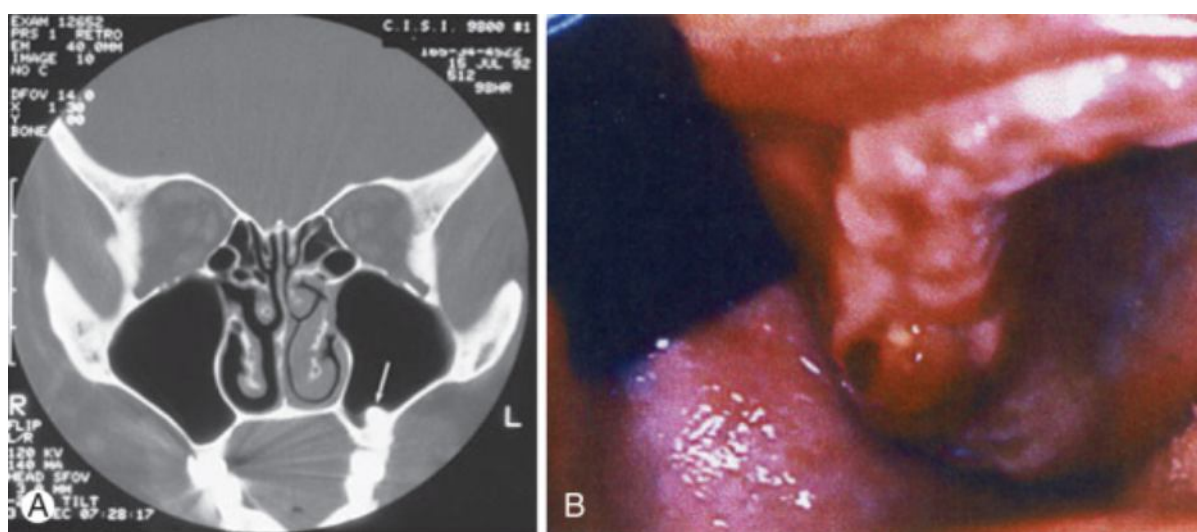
A, Computed tomography scan clearly demonstrating the relationship between a molar tooth (arrow) and a well-aerated maxillary sinus. B, Oral-antral fistula that developed after tooth extraction. The most common explanation for this is failure to provide adequate nasal drainage.
